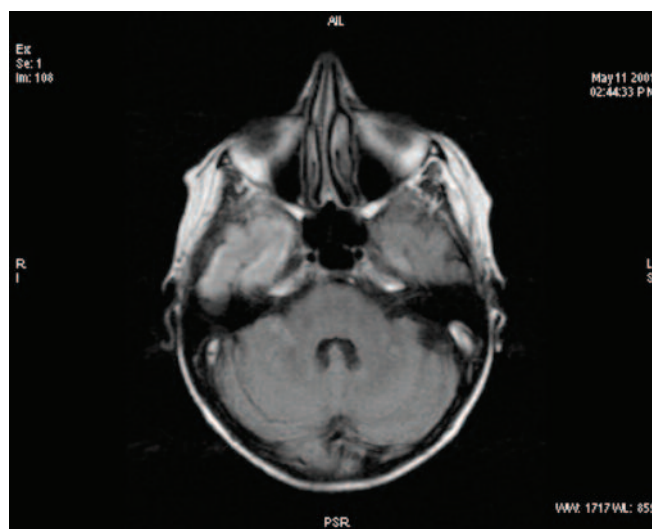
Axial FLAIR (2001) showing high signal in the right temporal lobe and a smaller area of high signal in the medial aspect of the left temporal lobe.
